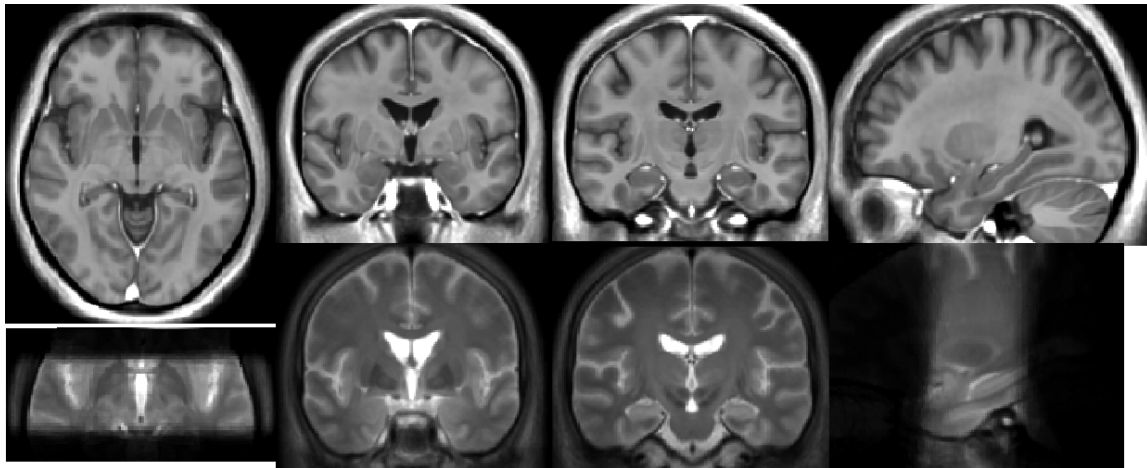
Parkinson's templates obtained from 57 T1w and 42 T2w average MR images of patients with Parkinson's disease. *From left to right:* Axial, coronal, coronal and sagittal slices of the T1w (*top*) and T2w (*bottom*) templates.
